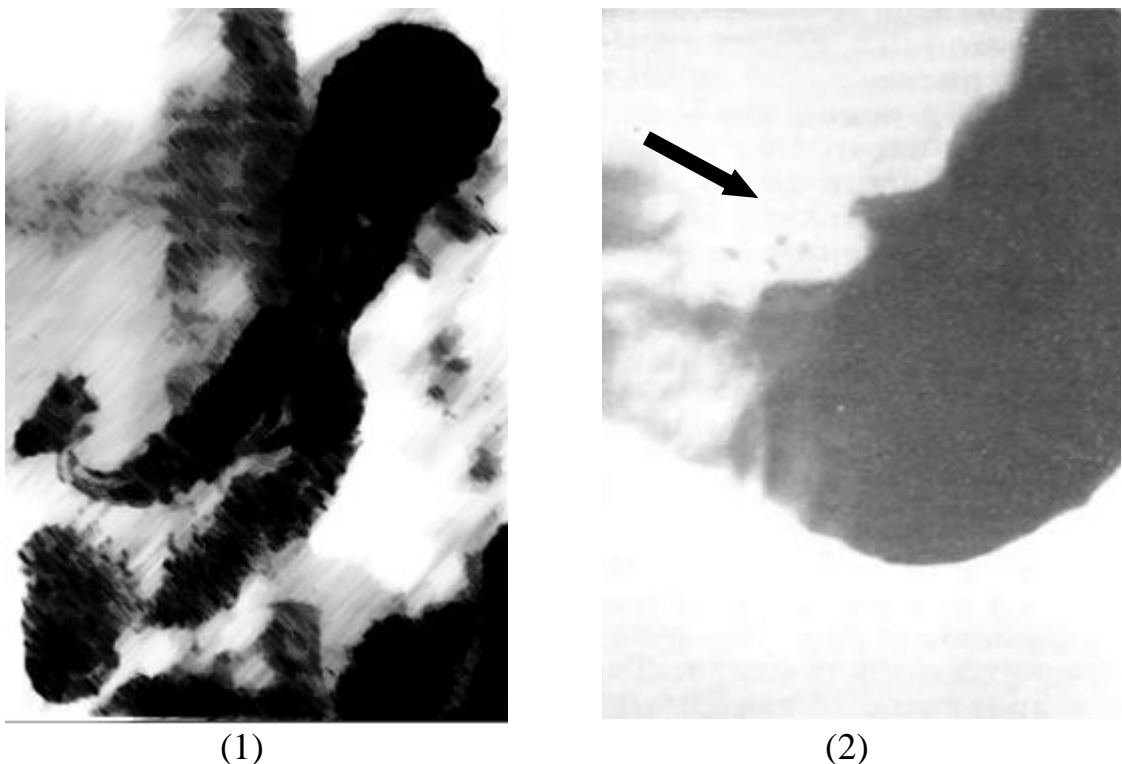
X-ray of the stomach:
